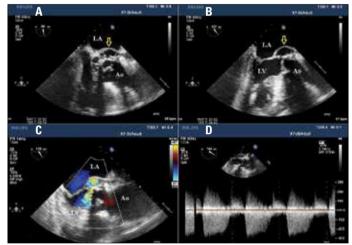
Two dimensional (2D) transesophageal echocardiographic views of pseudoaneurysm: (A) Parasternal short axis view; (B) Parasternal long axis view; (C) Color Doppler ultrasound image in the parasternal long axis view demonstrating fistulous communication between pseudoaneurysm and left ventricle outflow tract (D) CW Doppler ultrasound image in the parasternal long axis view demonstrating fistulous communication between pseudoaneurysm and left ventricle outflow tract (D) CW Doppler ultrasound image in the parasternal long axis view demonstrating fistulous communication
